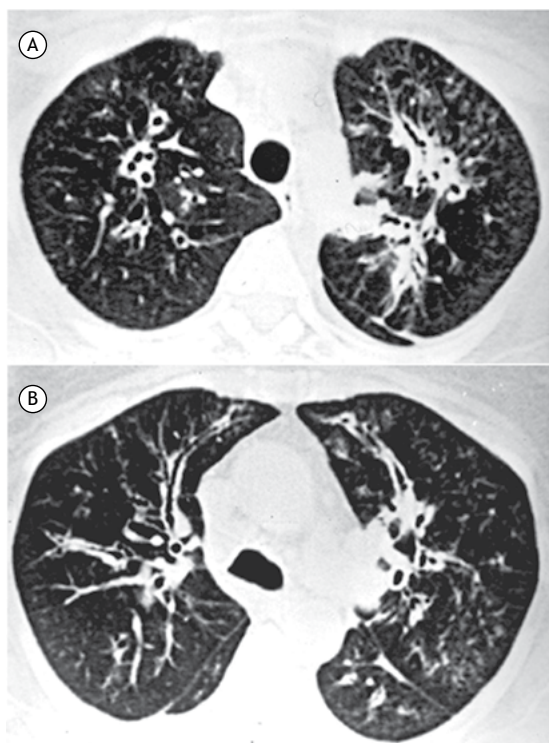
Axial CT scans at the level of the upper lobes showing marked thickening of the peribronchovascular interstitium bilaterally.
